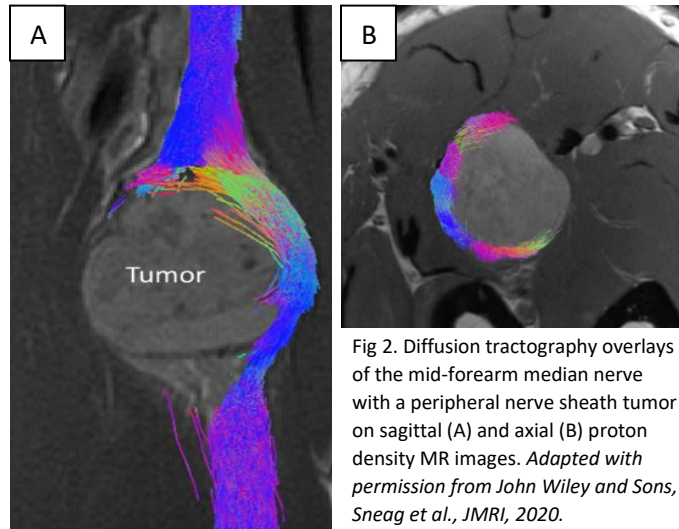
Diffusion tractography overlays of the mid-forearm median nerve with a peripheral nerve sheath tumor on sagittal (A) and axial (B) proton density MR images. Adapted with permission from John Wiley and Sons, Sneag *et al.*, *JMRI*, 2020.
